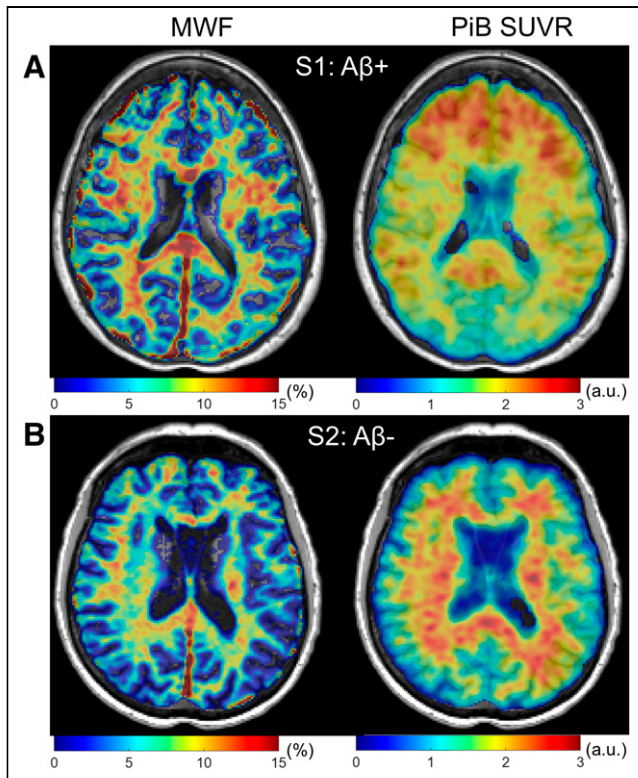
Representative images of MWF and A β PET SUVR in A β -positive patient (62-y-old woman with MCI/AD; A) and A β -negative patient (65-y-old, cognitively normal man; B) in Montreal Neurological Institute space.
